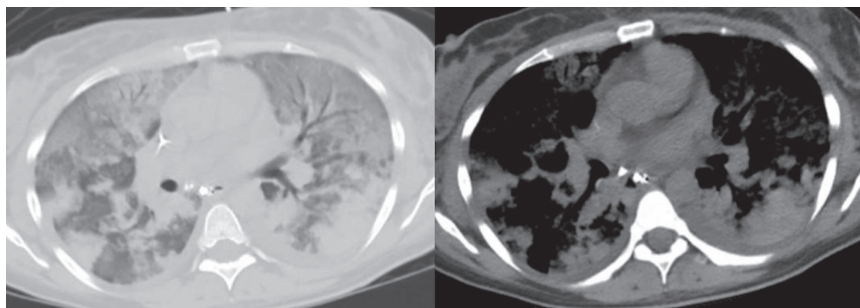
Chest computed tomography on day 5 showed patchy, multifocal lung consolidation with interstitial edema and small bilateral pleural effusions.
